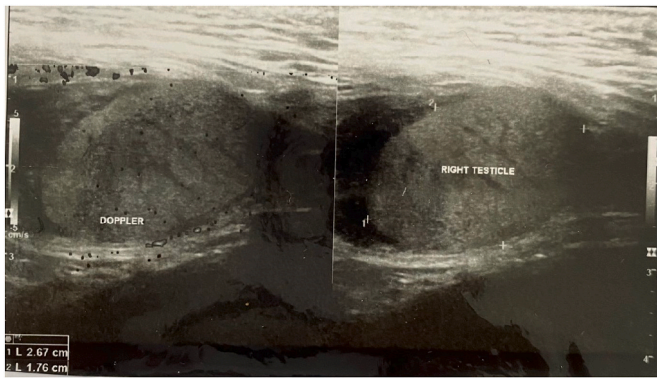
Doppler ultrasound images show a right inguinal testicle, a mass of about 2 cm in diameter in the right inguinal canal with no sign of blood flow.
